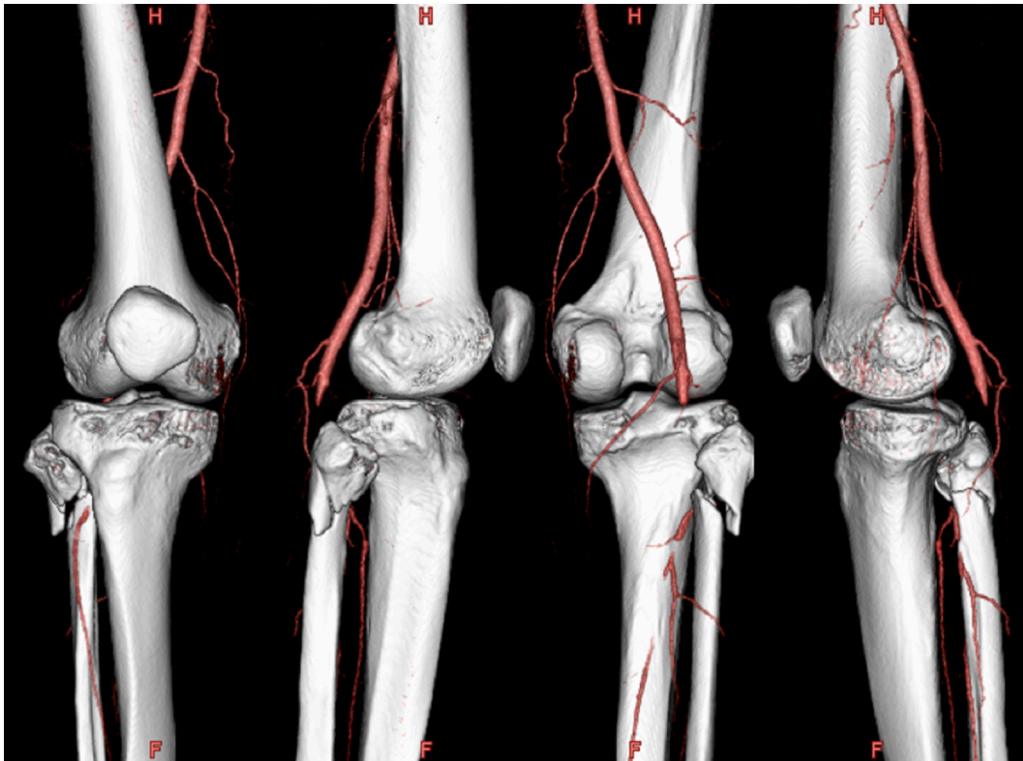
Computed tomography angiography at the time of transportation. It shows interruption of the popliteal artery at the knee joint level and extension of the artery on the distal side of the injury site. The remaining collateral circulation was evaluated.
